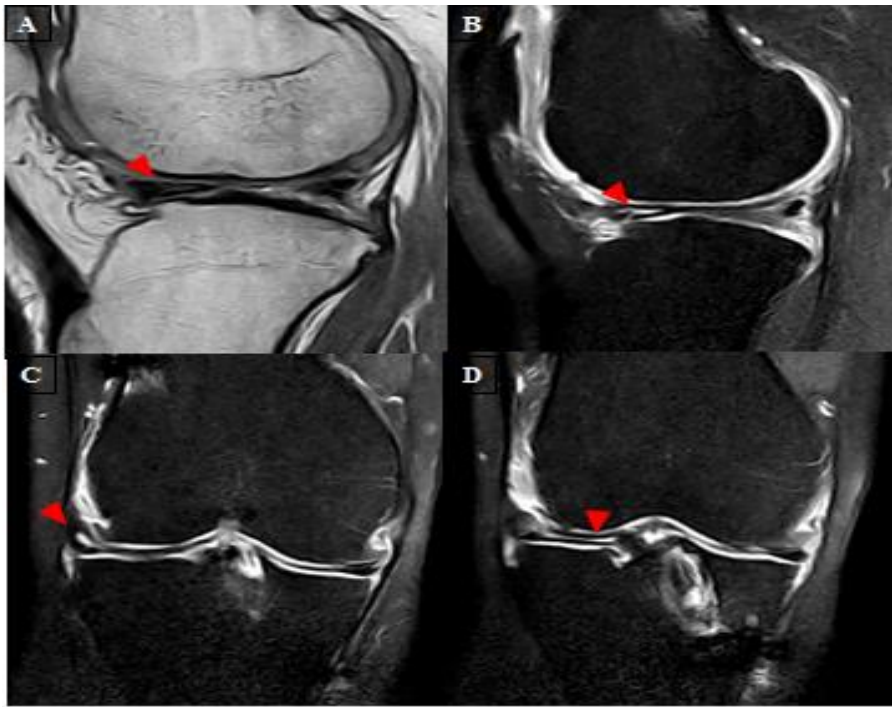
A, B, C & D): Recurrent anterior horn lateral meniscus tear in patient with partial meniscectomy. A): Sagittal proton-density MR images found faint linear signal not reaching articular surface. B & C): Sagittal & coronal T1-weighted, fat-suppressed, post-contrast sagittal MR images found contrast material extending through the meniscus (arrowheads) in keeping with recurrent tear D): Coronal T1 fat-suppressed post-arthrogram image found extension to meniscal root (arrowheads).
